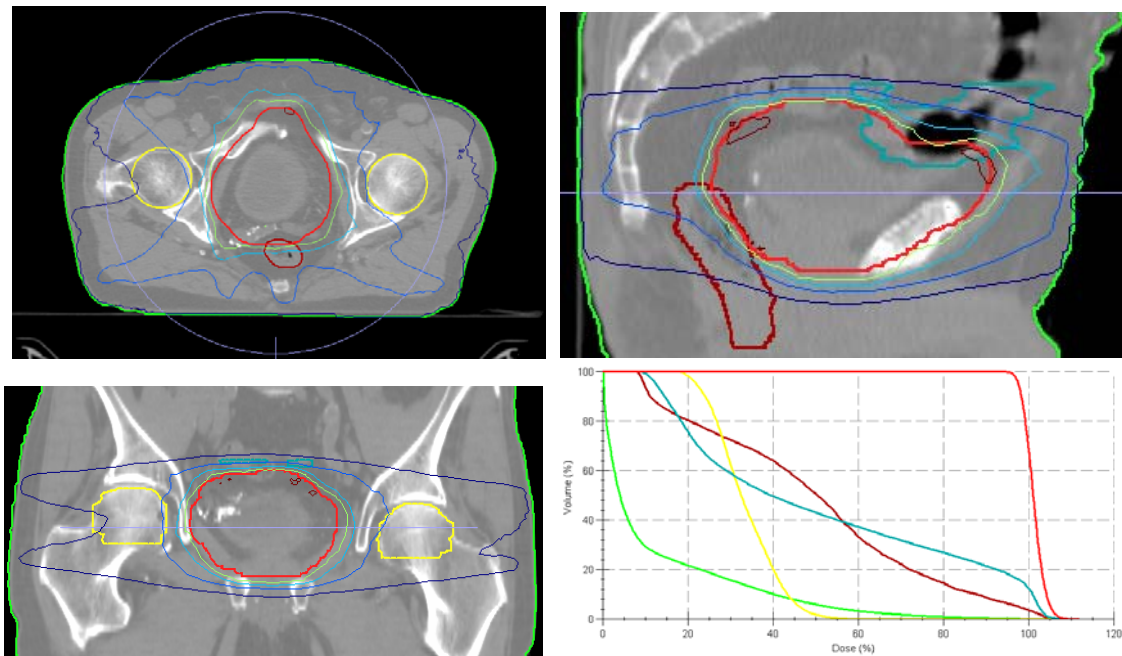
Planned dose distribution in a case, in which the whole bladder was treated. The amounts of doses in contoured structures can be seen in DVH, where red indicates the PTV, yellow the hip bones, turquoise blue the bowels, brown the rectum and green the body. In the slices of planning CT images the 107 % isodose is dark red, 95 % green, 80 % light blue, 50 % blue and 20 % dark blue.
